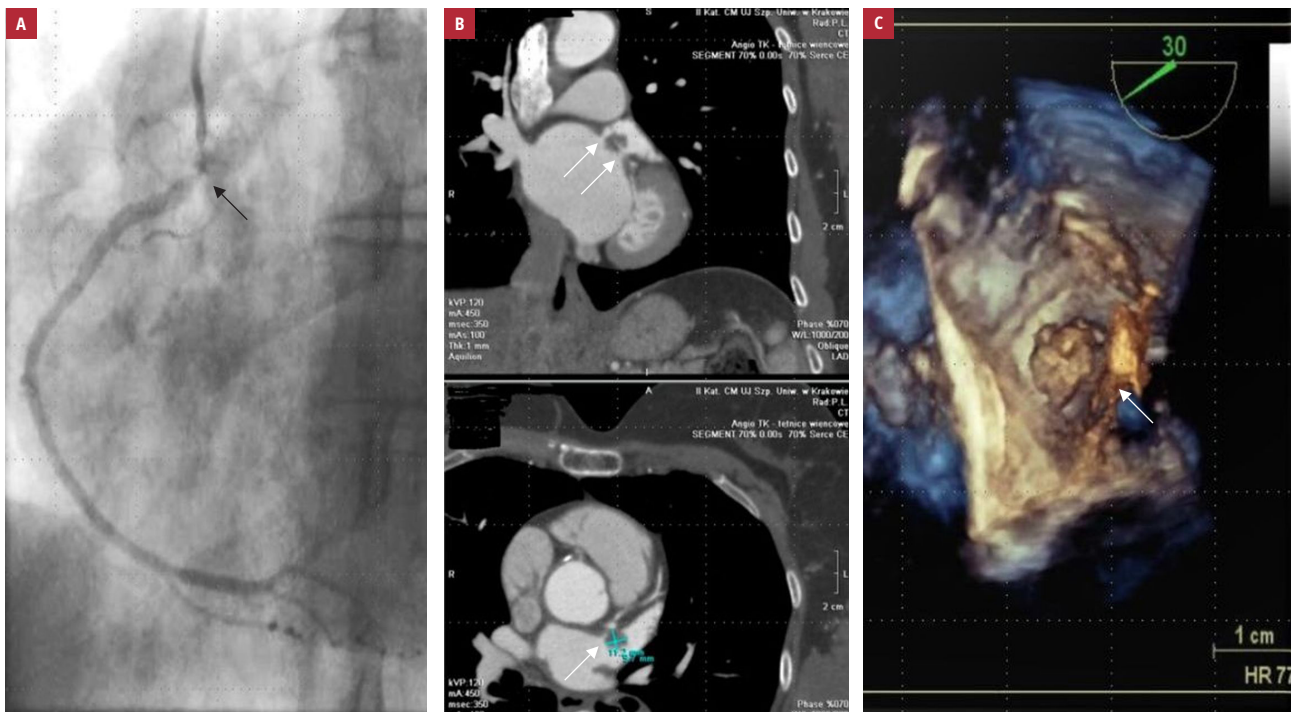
A – initial coronary angiogram of the right coronary artery, showing significant stenosis in the proximal part of the vessel (arrow); B – cardiac computed tomography angiography showing multiple masses in the left atrium (arrows); C – transthoracic echocardiogram showing a solid mass in the right atrium (arrow)
